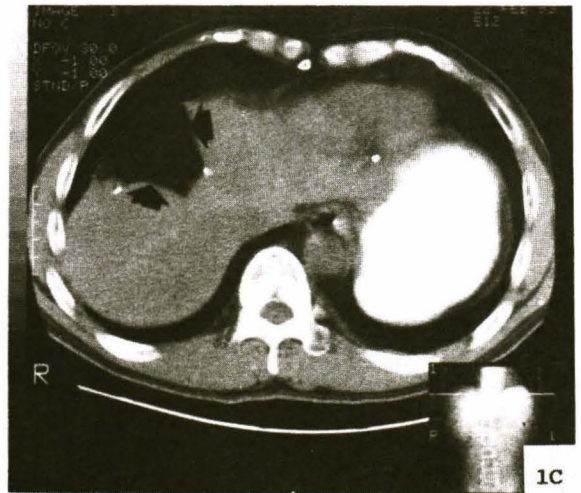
Same case as Fig. 1A, contrast enhanced CT upper abdomen after hepatic wedge resection of the tumor appears in Fig. 1B and the surgical defect is well demonstrated in CT scan (arrow).
